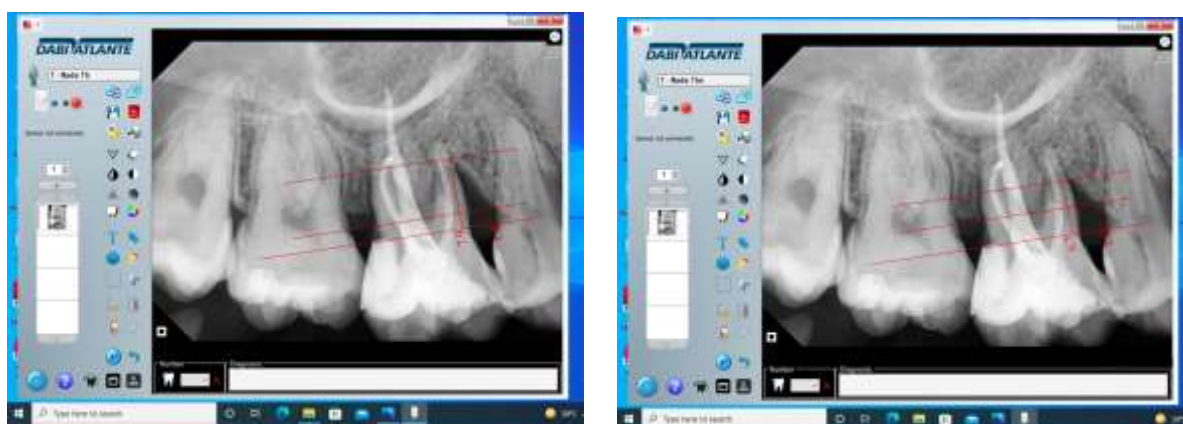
Radiographic measurements at (a) baseline and (b) 6 months postoperative showing hard tissue fill at the BD and AC resorption on the mesial aspect of the treated tooth.
